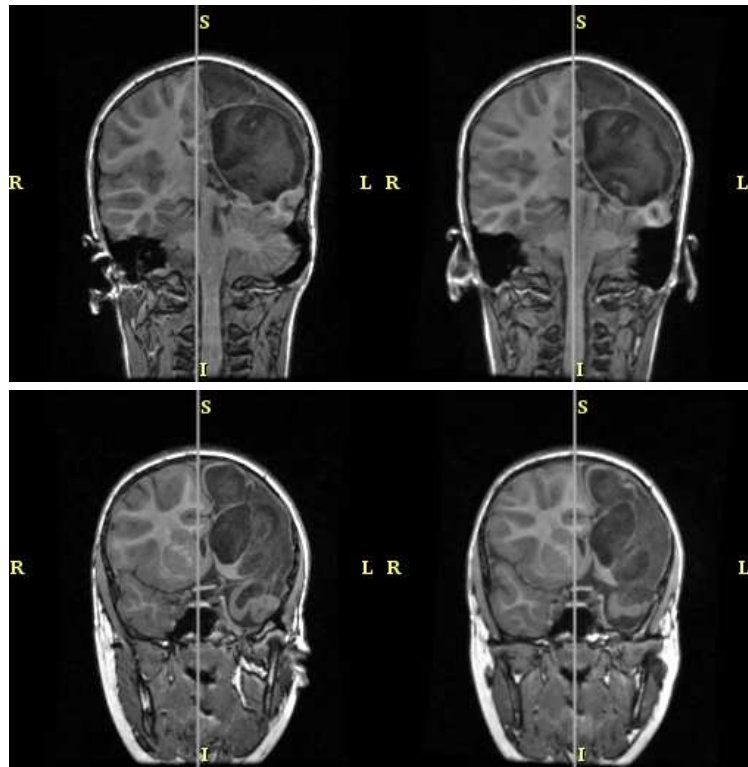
Plane of Symmetry Robustness Test Results - Coronal View. The left image of every pair shows the original T1-weighted MRI while the right image shows the volume aligned to the plane of symmetry. The gray line represents the plane of symmetry in the slice shown.
